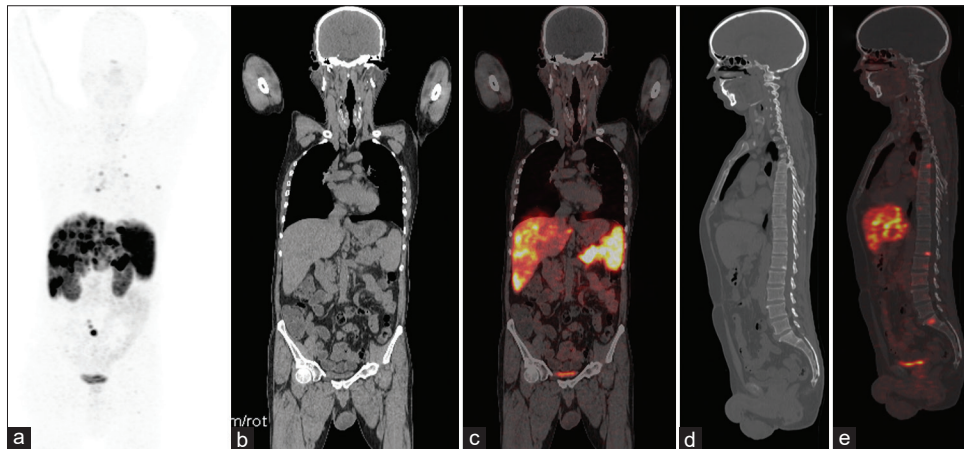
Case of 62-year-old male who was diagnosed with Neuro-endocrine tumor (Grade 2) of the Pancreas and was referred for Baseline 68Ga-DOTANOC Positron emission tomography/computed tomography (MIP [a], Coronal computed tomography [b], Coronal Positron emission tomography/computed tomography [c], Sagittal computed tomography [d], Sagittal Positron emission tomography/computed tomography [e]); which revealed a Somatostatin Receptor expressing metastases to the liver (b and c). Also noted were Somatostatin Receptor expressing skeletal metastases, some of which showed sclerosis in computed tomography (Lumbar lesion) and others did not (Thoracic and Sacral)
